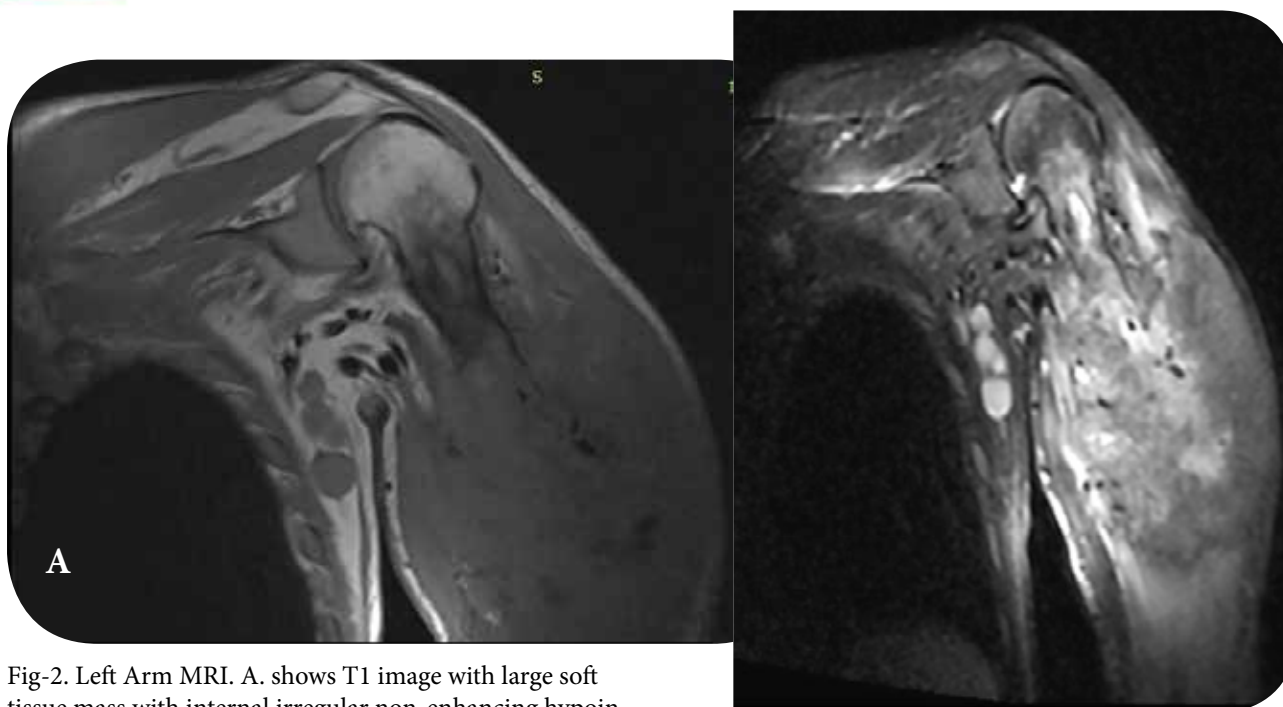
Left Arm MRI. A. shows T1 image with large soft tissue mass with internal irregular non-enhancing hypointense component. B. shows T2 image with heterogeneous signal intensity & multiple left axillary lymphadenopathies.
